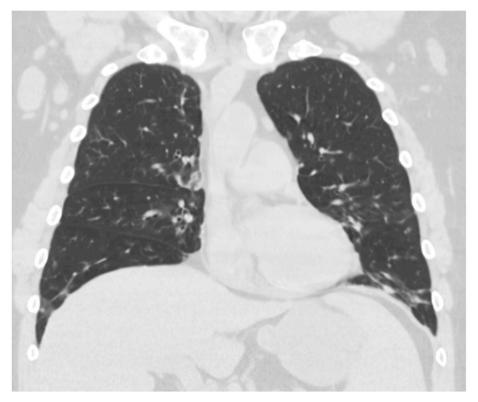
Coronal non-contrast CT chest - image demonstrating numerous, diffuse, ground glass nodular opacities.
